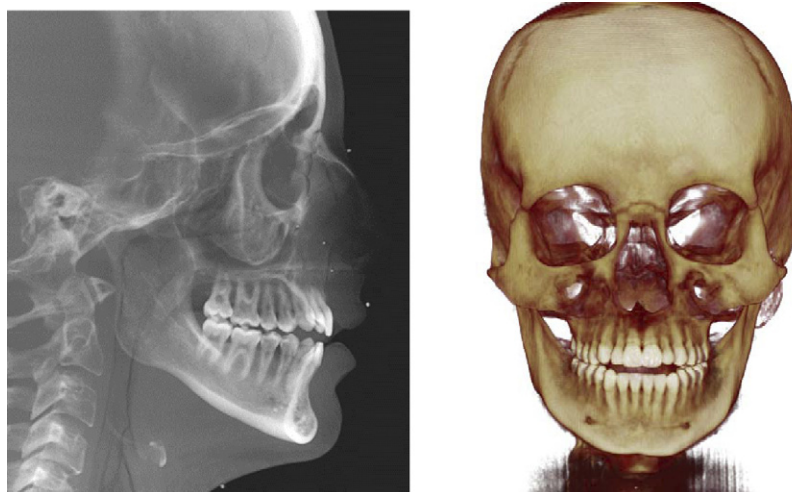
The head film and frontal cone-beam CT images of the patient in Figure 4 are shown. Note the Class II anterior open bite malocclusion. The etiology for this malocclusion is indeterminate but related to compressive and systemic overlay factors. Note that the mandibular midline is to the right and the right mandible is canted up, both findings related to the smaller right joint. (Color version of figure is available online.)
